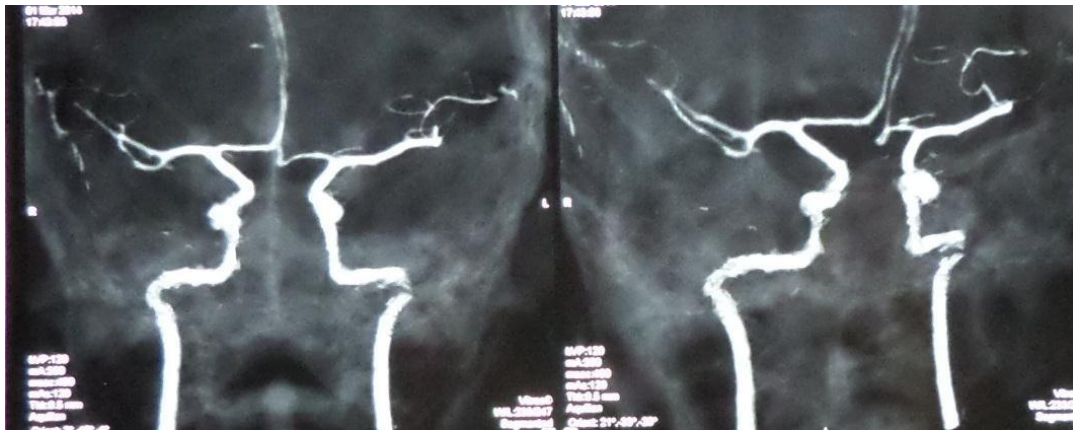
CT angiography showing a case of aplastic ACoA complex, representing the most common variant of ACoA complex
